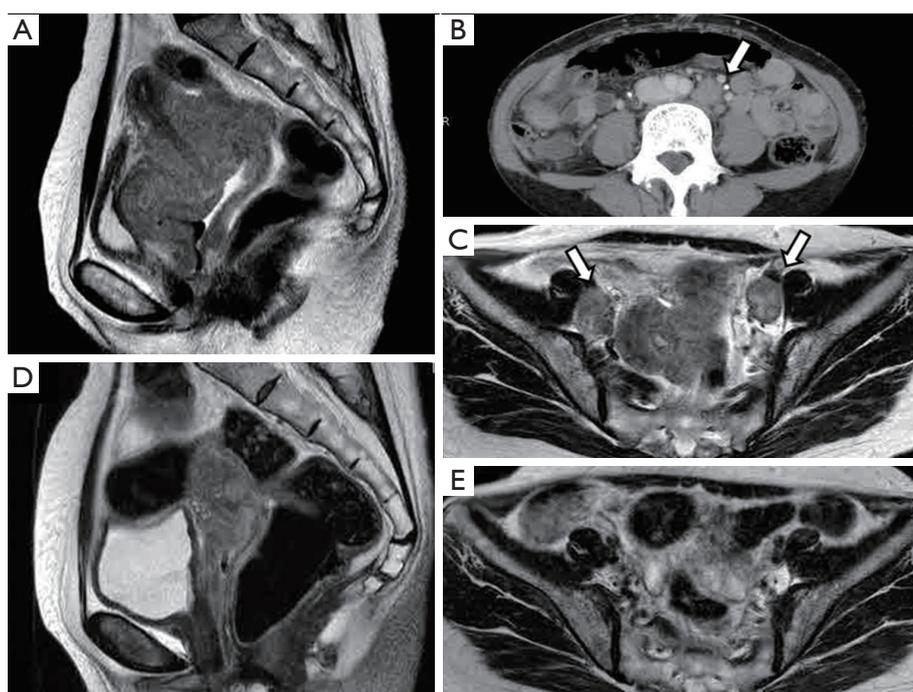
Neoadjuvant CT was remarkably efficacious in a patient who had a large-sized cervical tumor (A), para-aortic lymph node enlargement (B: arrow) and multiple pelvic lymph node enlargement (C: arrow). After one course of combined CT (PTX 180 mg/m² and cisplatin 60 mg/m²), the size of local disease was extremely reduced (D) and multiple lymph node enlargement disappeared (E). The patient received CCRT after two cycles of neoadjuvant CT and achieved a long-term disease-free survival period of 72 months. CT, chemotherapy; PTX, paclitaxel; CCRT, compare concurrent chemoradiotherapy.
